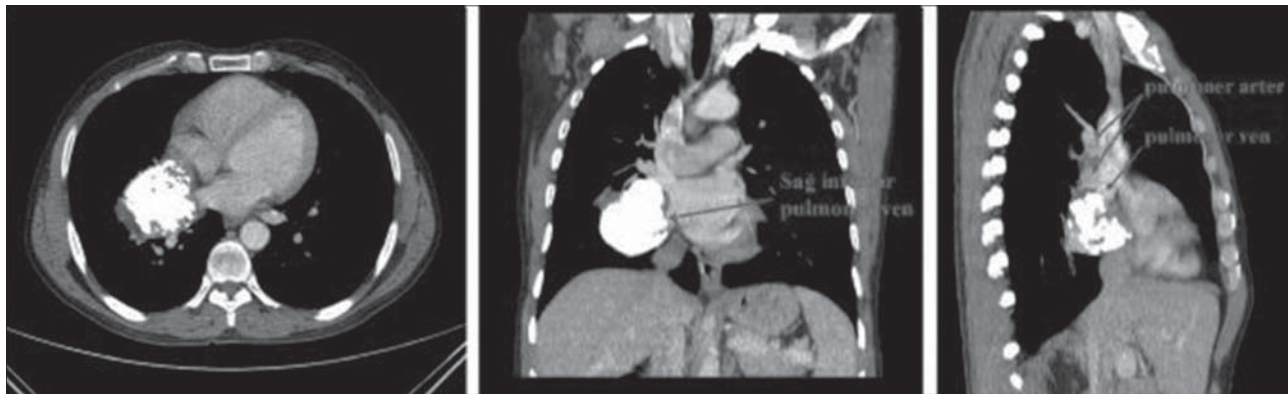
Thoracic CT sections of the patient.
